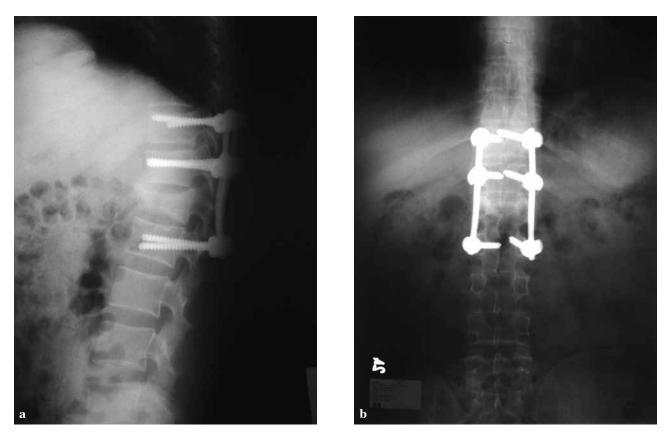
45-year-old male treated with instrumentation two segments above and one segment below the fracture level : (a) anterior and (b) lateral radiographs at the last follow-up.
